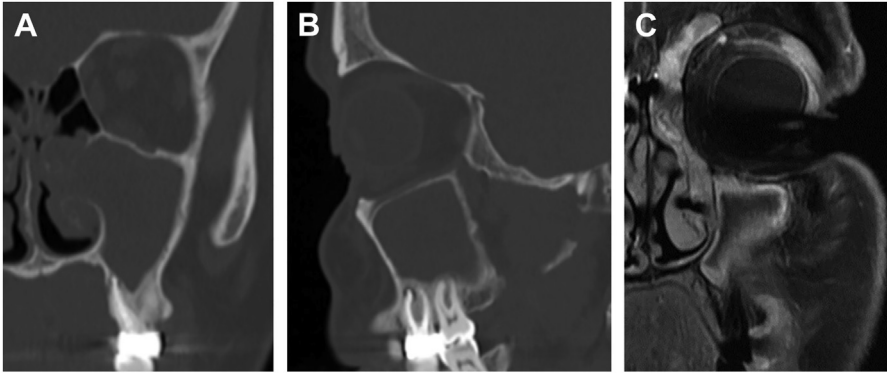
Example of persistent left-sided ODS affecting maxillary, ethmoid, and frontal sinuses despite successful RCT. (A) Coronal CT showing complete maxillary sinus opacification, and an adjacent molar that had a successful RCT to attempt treating the ODS (pre-RCT CT not shown). (B) Sagittal CT showing a complete RCT and the prior periapical radiolucency regressed to almost nothing. (C) Post-treatment MRI (obtained for non-sinusitis reasons), showing persistent inflammation and infectious secretions in the maxillary, ethmoid, and frontal sinuses. The patient underwent successful ESS to resolve this.
